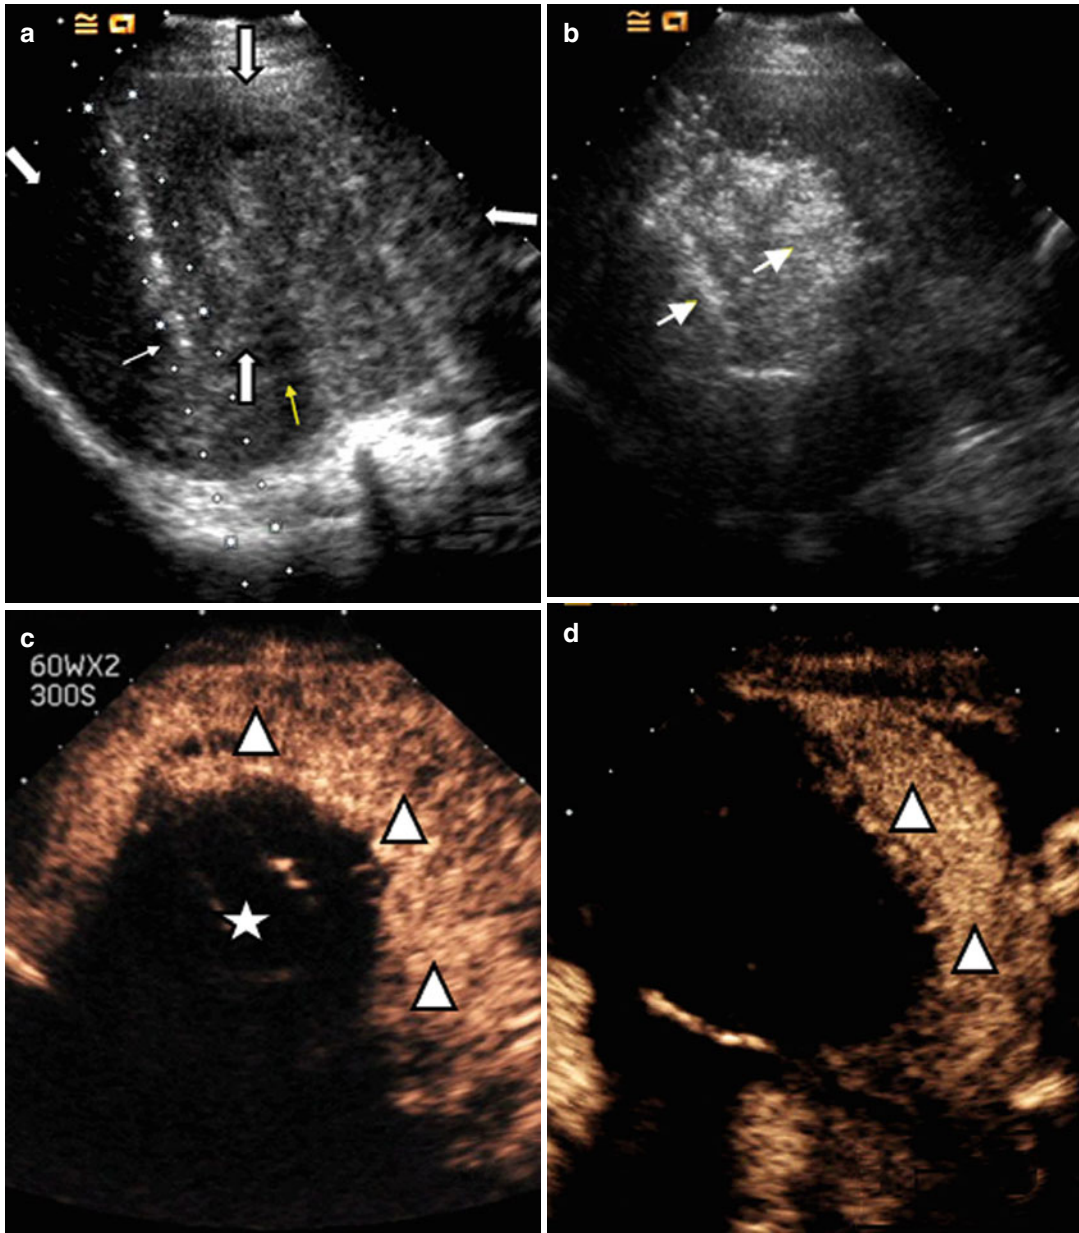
A 39-year-old woman who suffered from adenomyosis for about 5 years, with visual analogue scale (VAS) of 10, hemoglobin 106 g/l. Her uterine size was 11.5 cm×9.0 cm×11.3 cm, and the lesions are mainly located in the anterior wall. For her desire to reserve her uterus, she accepted microwave ablation (MWA). (a) Microwave antenna inserted into endometrial-myometrial area and the needle tip (small arrow) close to the far end of lesions (area between large arrows; the yellow arrow indicates endometrium). (b) Two microwave antennas (arrows) worked and the surrounding area turned to hyperechogenic (c) After 60 W×300 s, by two antennas, the non-perfused area (white star) in contrast-enhanced ultrasound (CEUS) was insufficient, and the triangle means the area that needs
